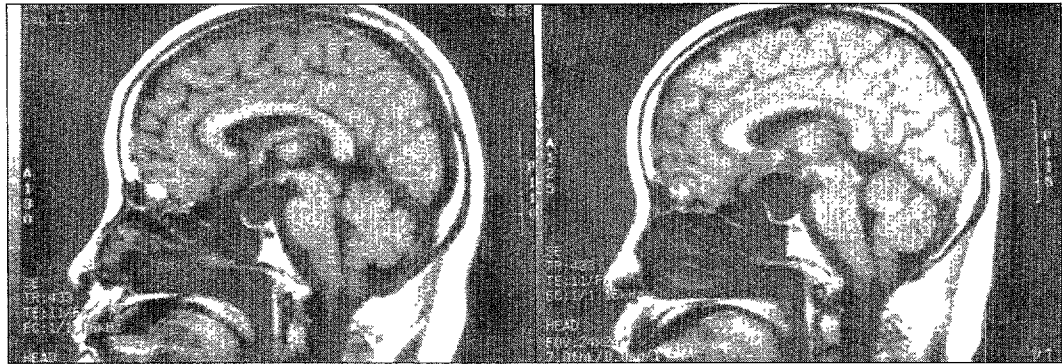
Case 5. Left : Sagittal T1-weighted magnetic resonance(MR) image revealing an arachnoid cyst in the pituitary fossa extending to suprasellar region with compression of optic chiasm. Right : Sagittal T1-weighted magnetic resonance(MR) image obtained 12 months after surgery demonstrating cyst reduction and release of chiasmatic compression.
